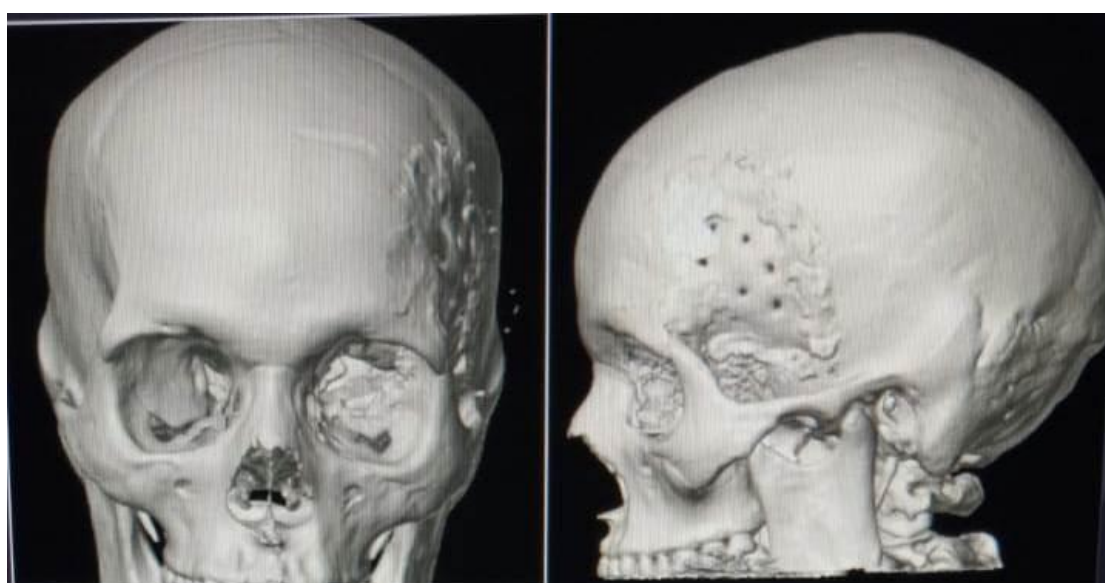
3D reconstruction of CT brain post-operative
